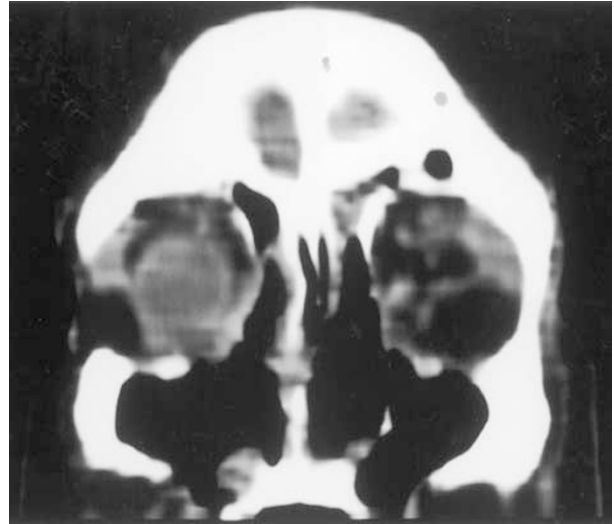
Destructive effects of WG: CT scan, reformatted coronal view. The left eye required enucleation following scleritis-induced perforation. Extensive sinonasal destruction with partial loss of the inferomedial orbital walls and nasal septum.
